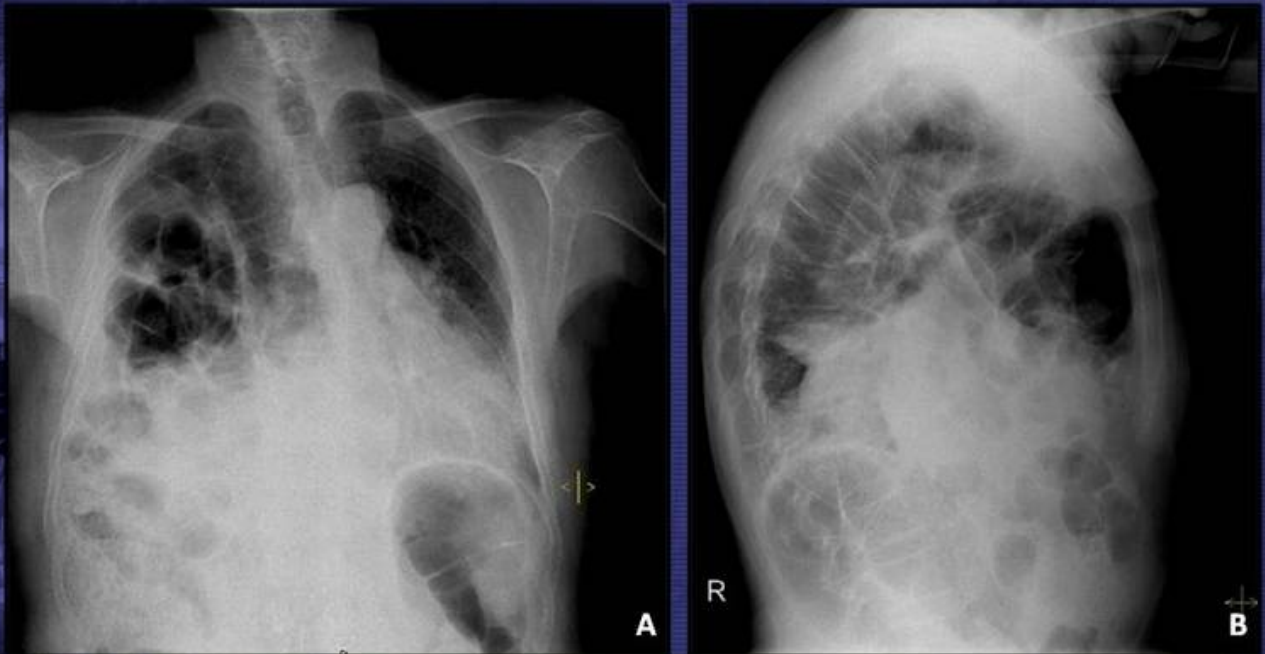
Frontal (A) and lateral (B) chest plain films show a traumatic diaphragmatic hernia, with uncommon rupture of the right side of the diaphragm, with herniation of abdominal contents (namely colon) into the thoracic cavity. Note also the mediastinum shifted to the left.
